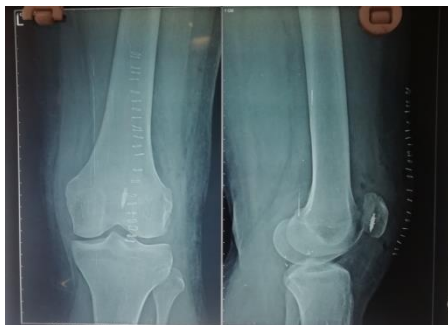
Post operative X-ray with suture anchor.
